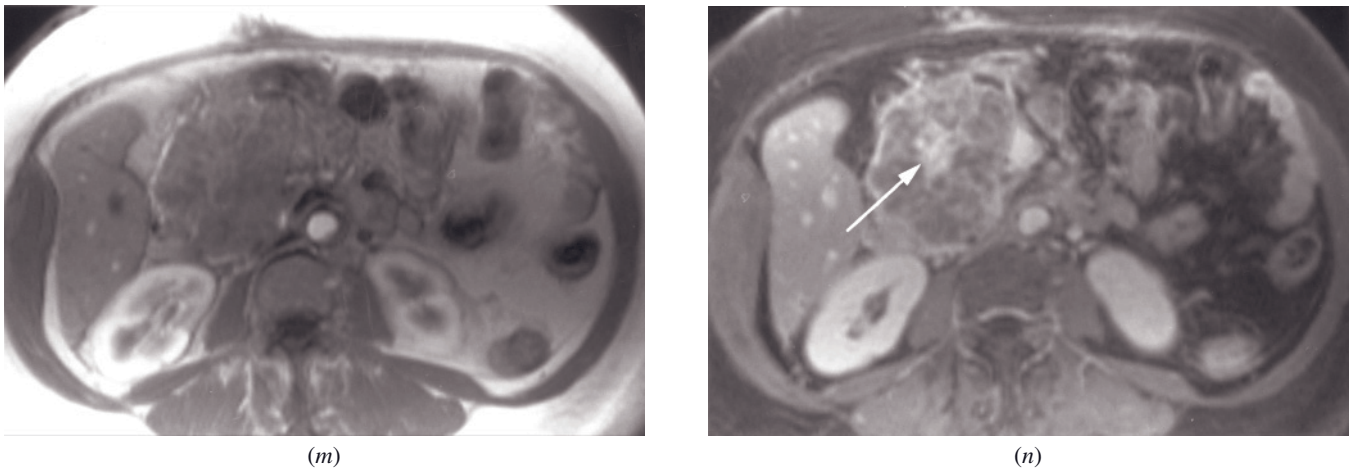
(Continued) of the pancreas, best shown on the single-shot T2-weighted sequence. There is a central scar, typical for serous cystadenoma, which enhances on late images (arrow, *n*), consistent with fibrosis. Serous cystadenomas occur predominantly in women, as seen in these cases. The importance of the MR study is to differentiate this benign entity from mucinous cystadenomas that are potentially malignant.
